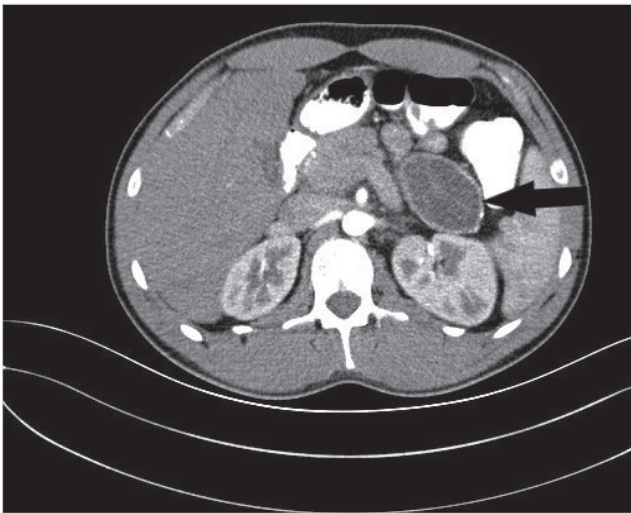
An image from computed tomography scan of patient. Black arrow represents pancreatic hydatid cyst.
